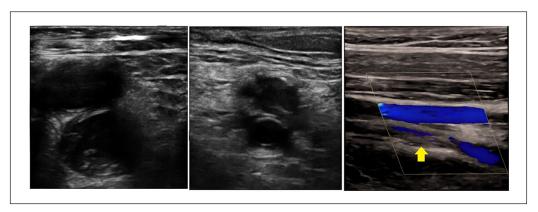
Ultrasound of the left leg showed dilated femoral vein (left image) (artery on top of vein) and dilated popliteal vein (center image) along with echogenic material suggestive of thrombus. Doppler ultrasound of left femoral vein with thrombus (yellow arrow) (right image).
